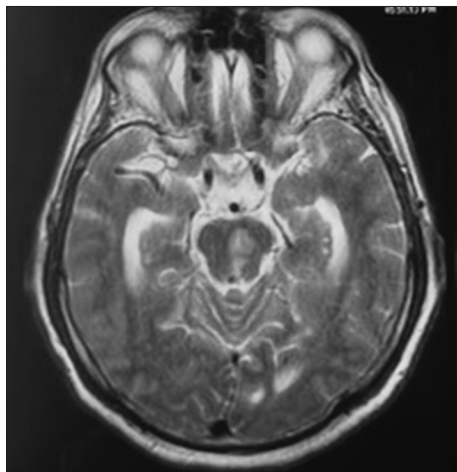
Left paramedian pontine infarct in axial T2-weighted magnetic resonance imaging brain
